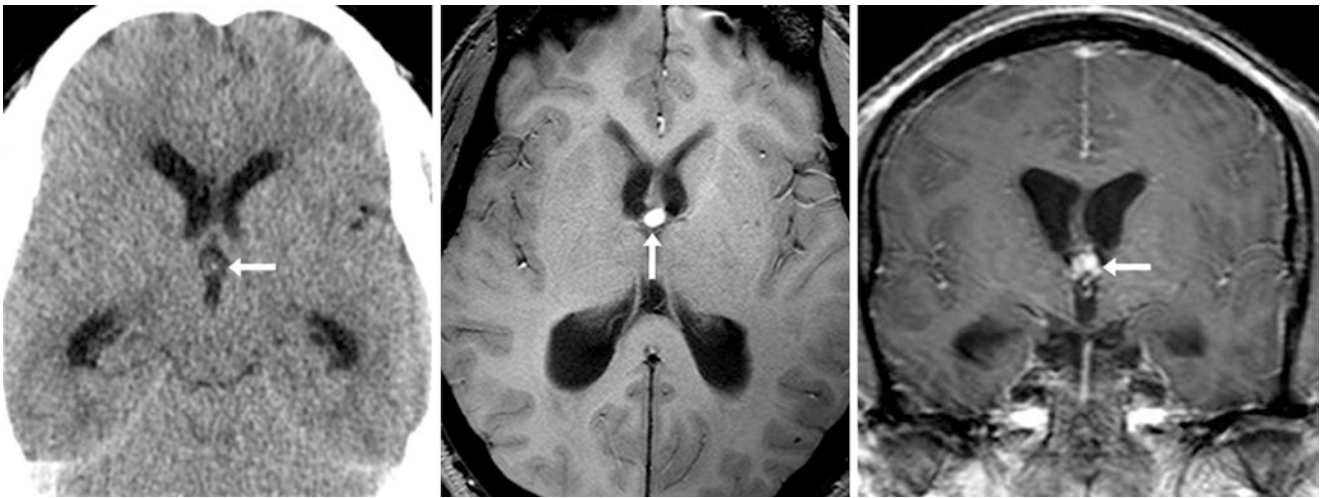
Comparison case of neurocysticercosis (colloidal vesicular phase): a 27-year-old patient with hydrocephalus. An intermediate density lesion (arrows) in the third ventricle on NECT (left) was bright on noncontrast T1WI (right) and obstructed CSF flow. A colloid cyst may appear similar on MRI but is usually hyperdense on CT
